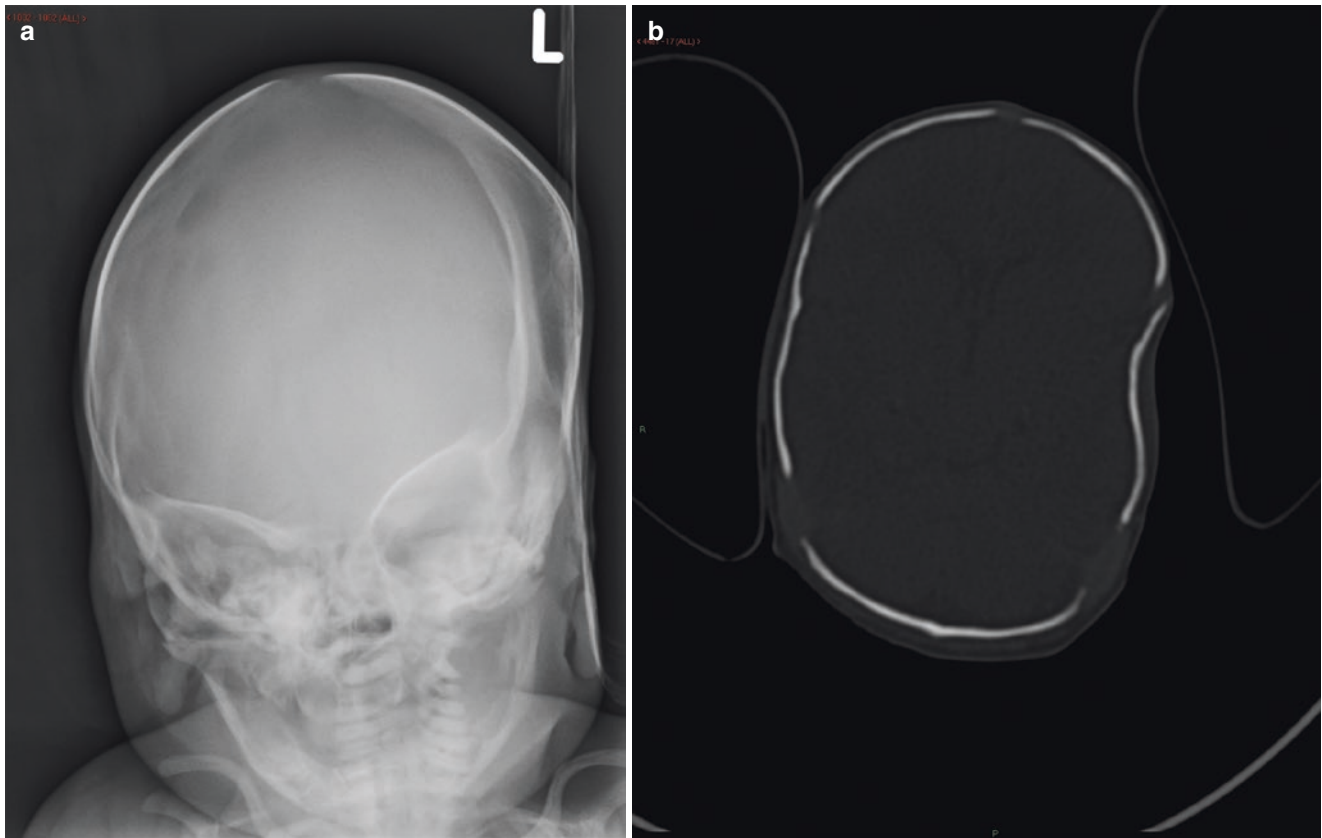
Left-sided ping-pong (pond) skull fracture. (a) AP skull radiograph in a newborn infant demonstrates a shallow depression of the left skull contour. (b) Axial CT image shows a shallow depression in the left parietal bone. No fracture line is demonstrated
